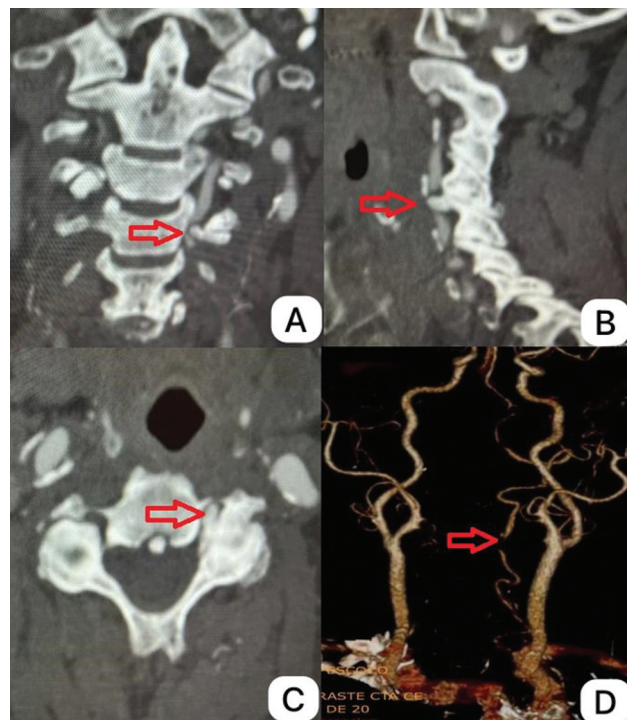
CT of cervical vessels - coronal (A), sagittal (B), and axial (C) views showing osteophyte invading the vertebral foramen, with 80% occlusion of its diameter and compression of the left vertebral artery. Originating from the superior articular facet of the fifth cervical vertebra. Image D, 3D reconstruction showing interruption of flow through the left vertebral artery (red arrow).
